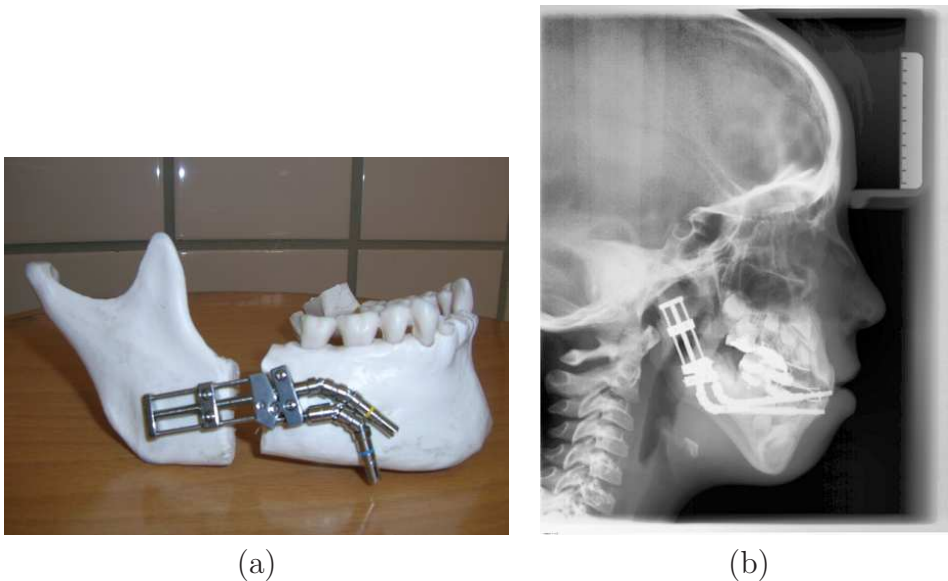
a) Intraoral distraction device of the patient; b) Radiography of the patient showing the intraoral device used in the treatment.
